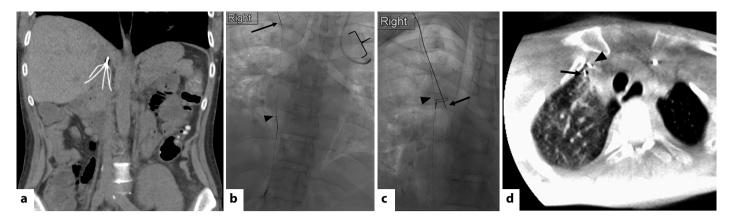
(a) Coronal non-contrast computed tomography showing the filter position within the hepatic inferior vena cava. (b) Fluoroscopic image demonstrating the initial needle pass (arrow) and snared wire (arrowhead). The left internal jugular central line (brace) is incidentally seen. (c) Fluoroscopic image showing the second, more medial approach (arrow). The wire from the initial puncture remains in place (arrowhead). (d) Axial cone beam computed tomography demonstrating the positions of the first (arrow) and second (arrowhead) passes.
